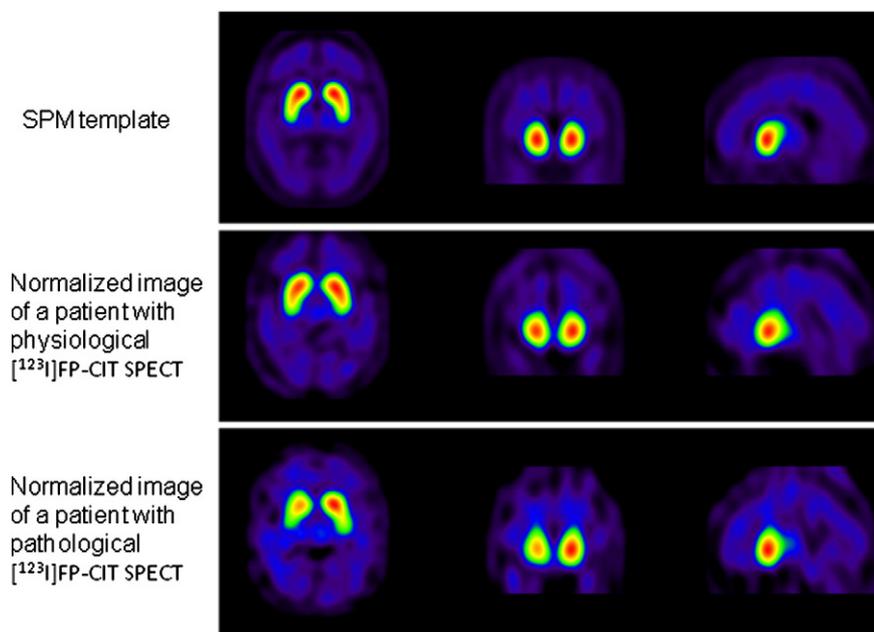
The figure shows the normalized image of two patients on the SPM template (first row): one with a physiological [^{123}I]FP-CIT SPECT (second row) and one with a pathological [^{123}I]FP-CIT SPECT (third row).
